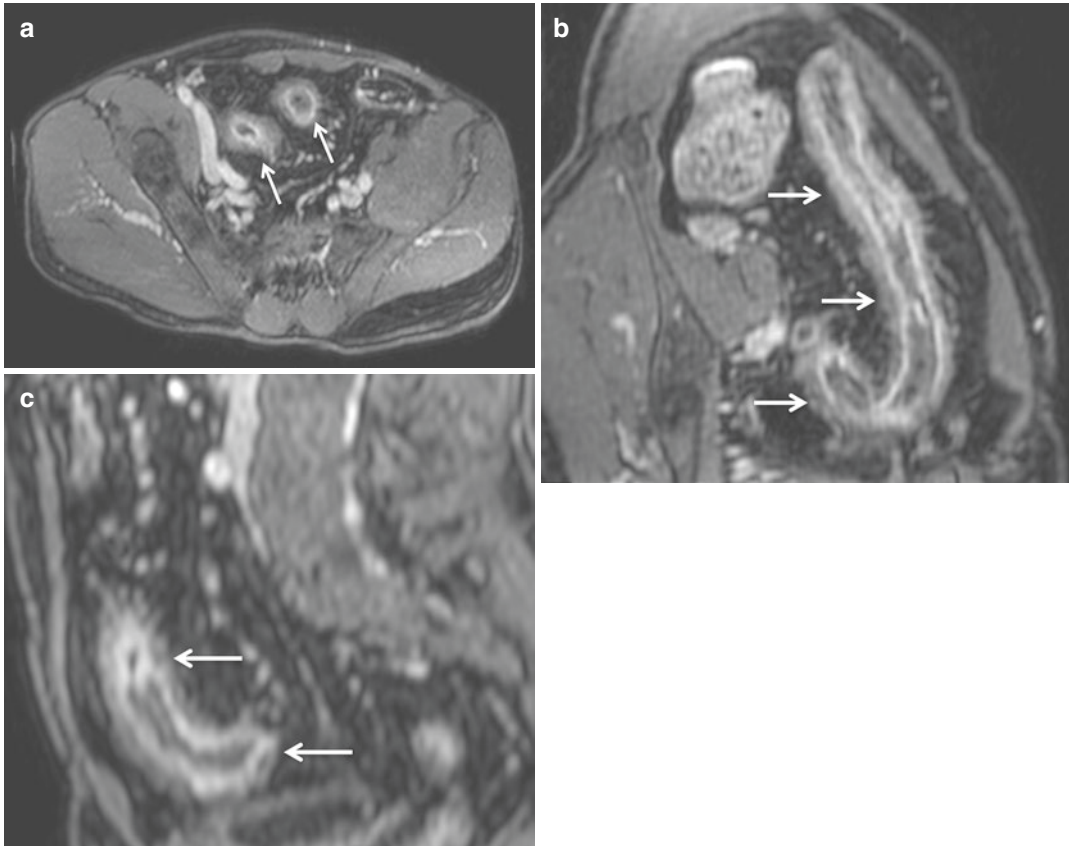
Axial fat-suppressed 3D GE T1-weighted image obtained after i.v. contrast material injection (a) in a patient with active inflammation of an ileal loop (arrows).
